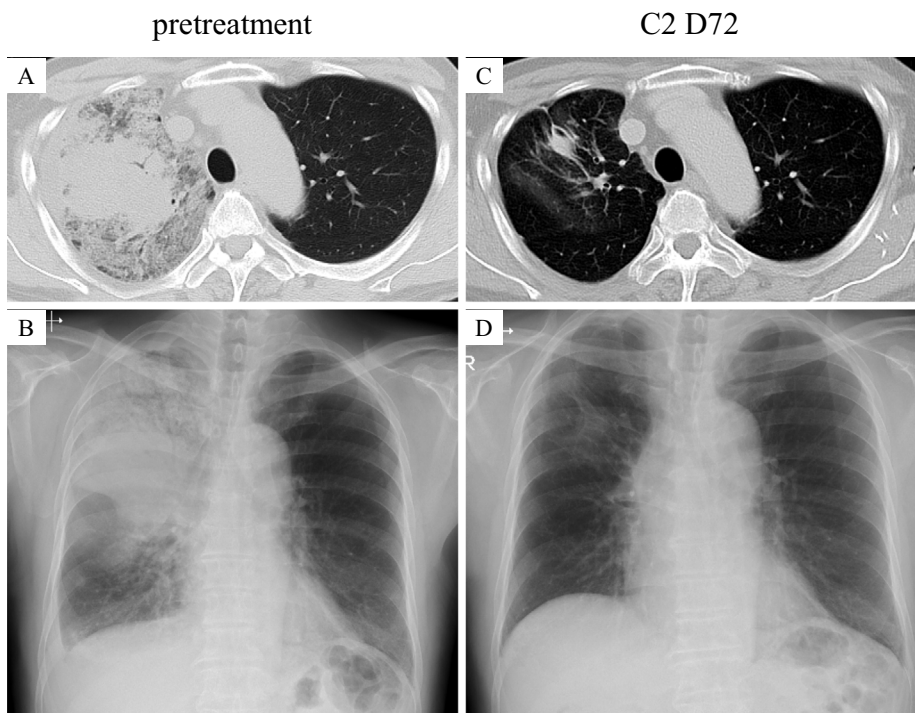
The course of treatment for lung cancer. (A, B) Pretreatment chest X-ray and CT showing the primary lesion in the upper lobe of the right lung. (C, D) Chest X-ray and CT findings 72 days after last chemotherapy, showing that the tumor had maintained 90% reduction in size according to the Response Evaluation Criteria In Solid Tumors (RECIST) version 1.1. CT: computed tomography
